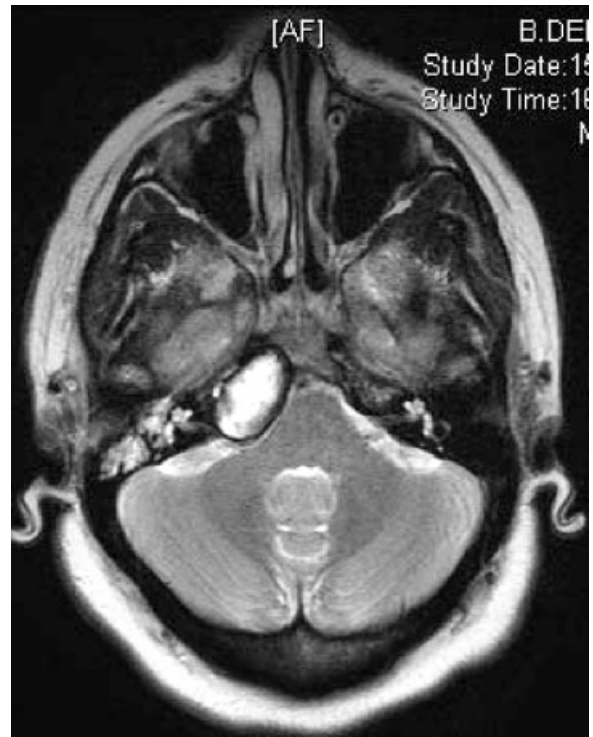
Magnetic resonance imaging (MRI) of the head demonstrating a large lesion with high signal in the right petrous apex (case 2).
